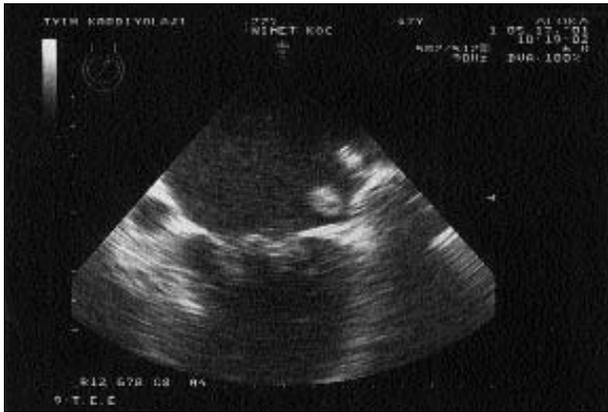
Transthoracic echocardiography of FFLABT in patient's first admission.
